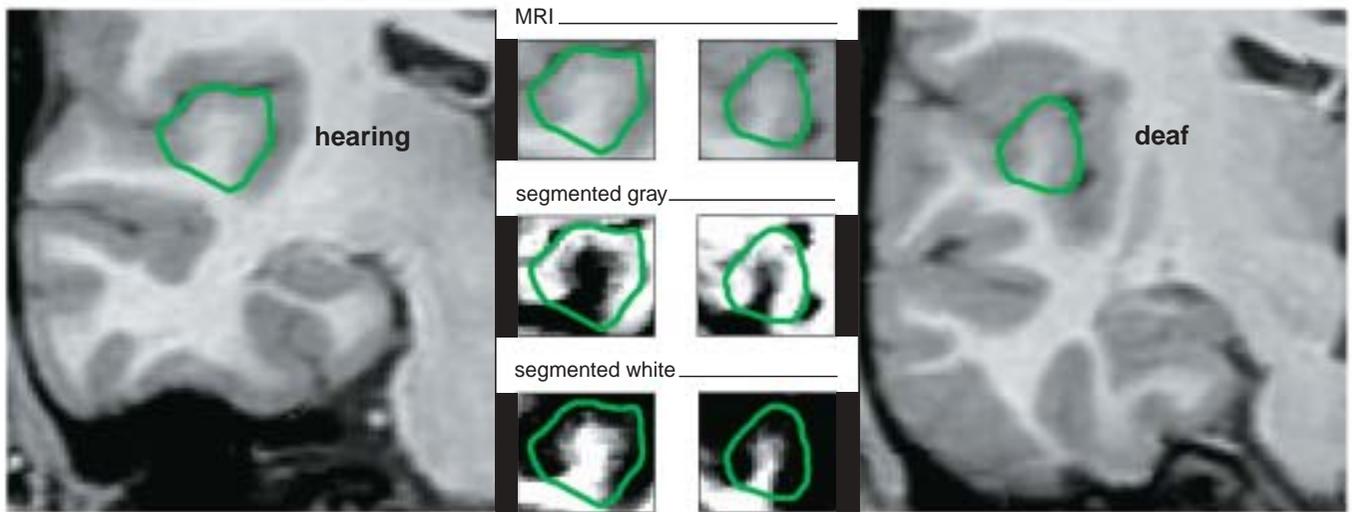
Congenitally deaf people have less white matter than do controls in Heschl's gyrus, the primary region for processing sound. Heschl's gyrus is outlined in green. The original MRI has been segmented into separate gray-matter and white-matter images for comparison.
